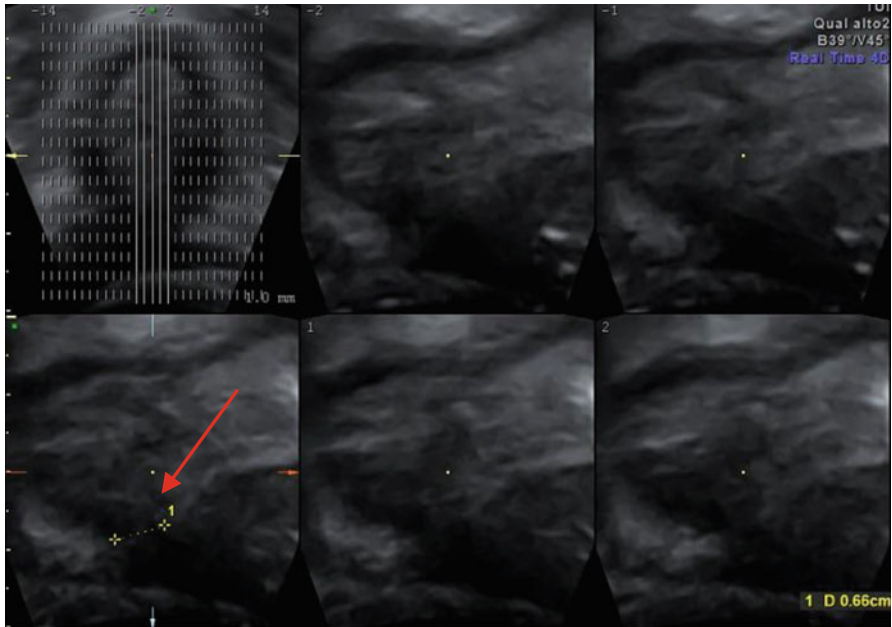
Tomographic ultrasound imaging (TUI) of anatomic defect (*arrow*) seen on multiple midsagittal planes
